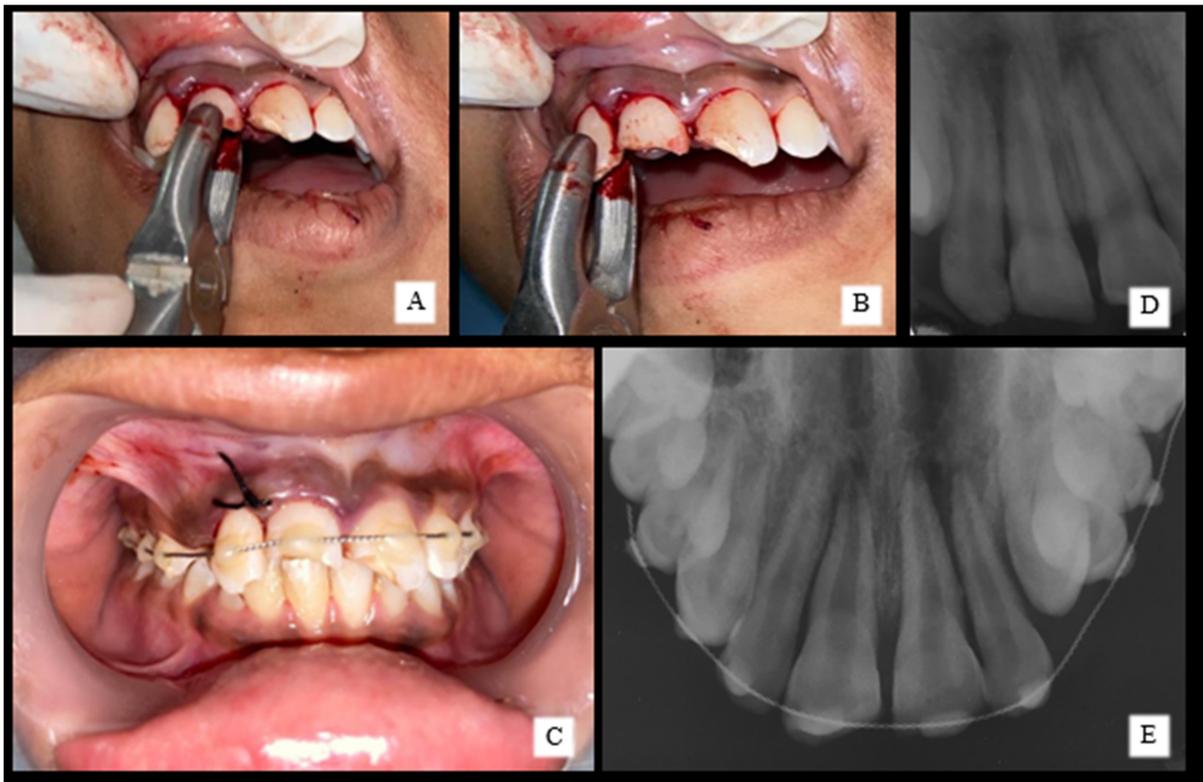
Surgical Extrusion of #12(A) , Surgical Intrusion of #11(B), IOPA After surgical repositioning(D), Placement of flexible splint(C), Occlusal Radiograph after splinting(E)
